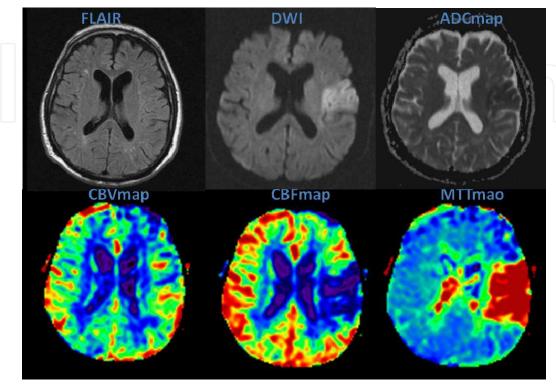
Imaging of an acute ischemic lesion in a 45 yrs old female with NPSLE and antiphospholipid syndrome (APS), 4 hours after the onset of the symptoms. FLAIR is unremarkable, while the lesion is revealed on DWI and ADC map as hyperintense and hypointense area, respectively, due to cytotoxic edema. Dynamic Susceptibility Contrast (DSC) MR Perfusion technique shows mild increased cerebral blood volume (red on CBV map), decreased cerebral blood flow (dark blue on CBF map) and increased mean transit time (red on MTT map)
